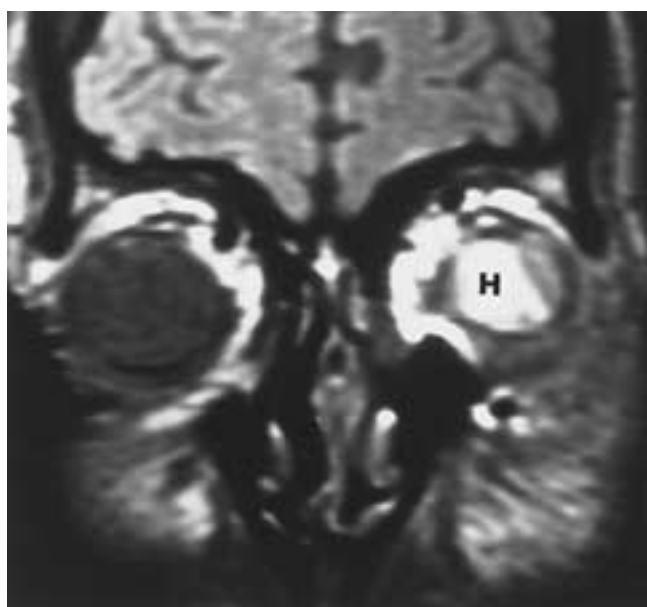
Chronic hemorrhagic choroidal detachment. Coronal PW MR image shows a hyperintense choroidal hematoma (*H*).
